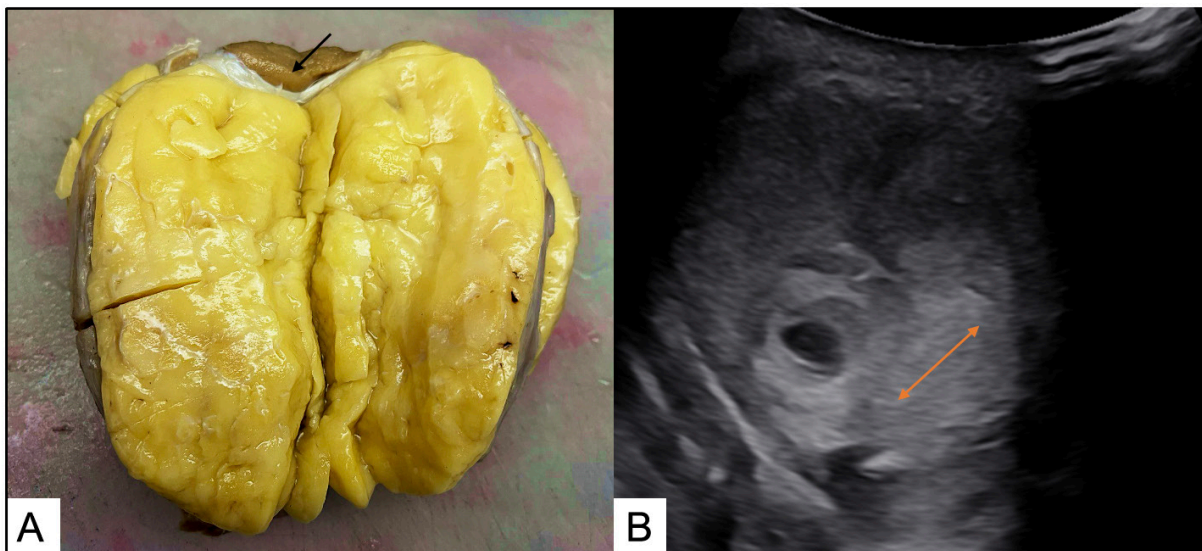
A) Gross image showing an encapsulated lipomatous lesion with normal compressed testes in periphery marked by arrow; B) Ultrasonographic picture showing weakly vascularized homogenous mass in right scrotum marked by arrow.
